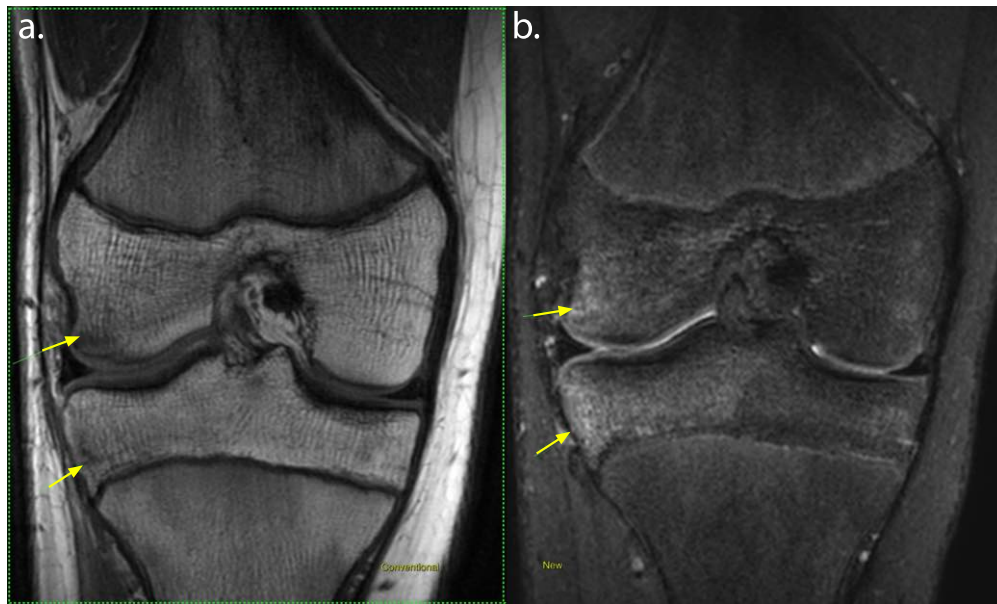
Patient presented with knee pain and clinical indication of meniscal tear. (a) Coronal T1, and (b) T2 Shuffling reformatted to coronal T2 MRIs are shown. The MRI finding was bone bruise, as indicated by the yellow arrows.
